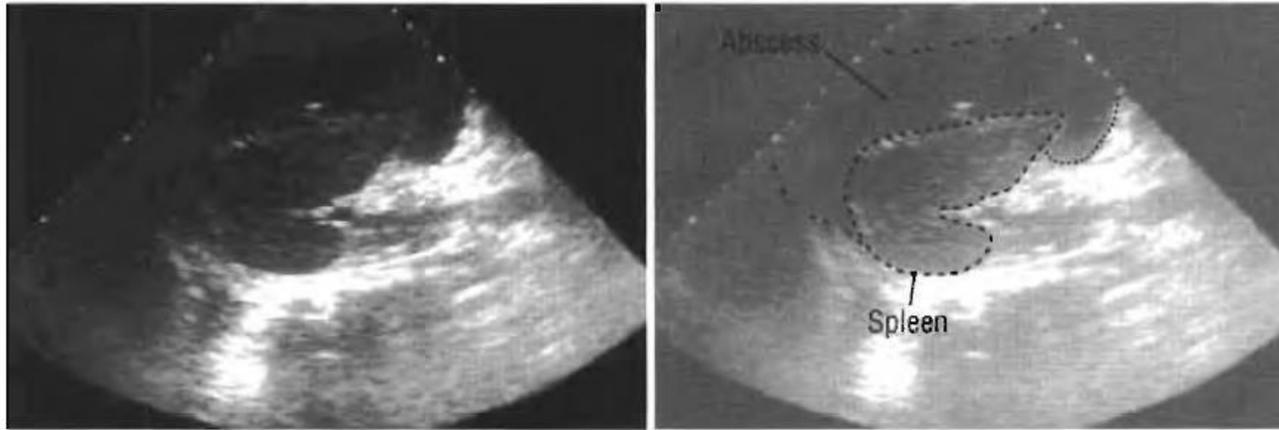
Longitudinal scan: a collection of fluid around the spleen; this was a perisplenic abscess, but the type of fluid can seldom be identified with an ultrasound scan.
